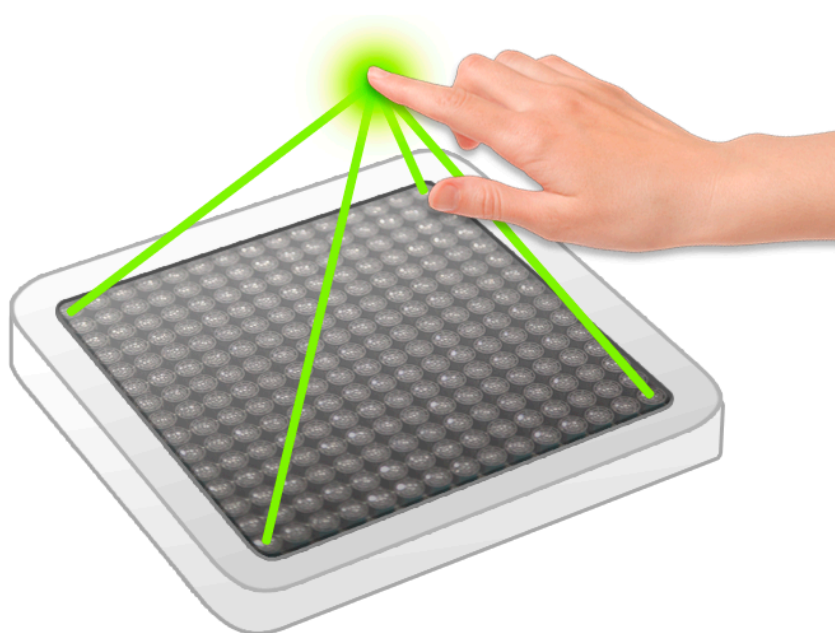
Ultrasound haptic displays use an array of ultrasound speakers to create tactile sensations in mid-air.
